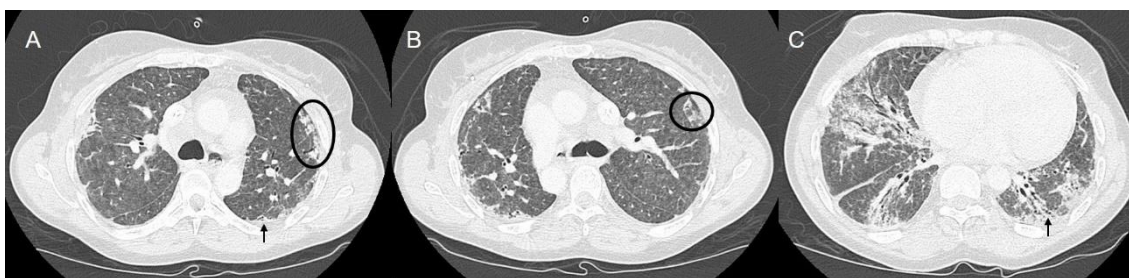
Chest computed tomography showing ground glass opacities, with subpleural sparing (circle) and traction bronchiectasis (arrow). At lower lobes there are foci of patchy consolidation with air bronchogram (C).
